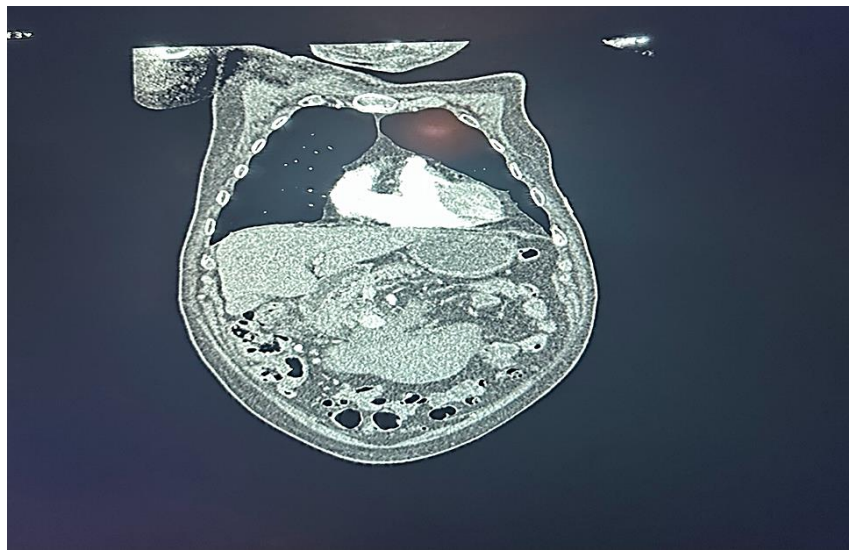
CT abdomen showing the pseudoaneurysm of the SMA (showed by the arrow)
